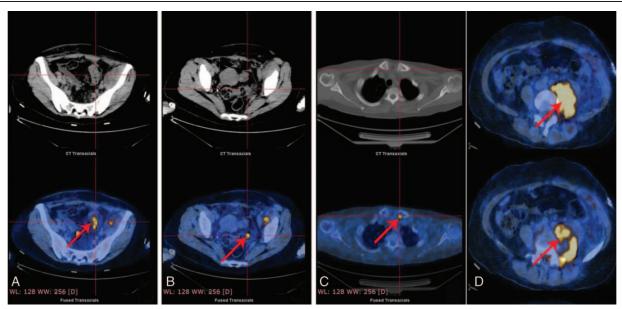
¹⁸F-FDG (fluorodeoxyglucose) positron emission tomography - computed tomography. (A) The arrow showed the sigmoid colon wall thickening with hypermetabolic foci and abnormal radioactivity concentration. (B) The arrow showed the multiple lymph nodes in pelvic cavity with hypermetabolic foci and abnormal radioactivity concentration. (C) The arrow showed the bone destruction of left extremitas sternalis claviculaeta with locally hypermetabolic foci and abnormal radioactivity concentration. (D) The arrows showed the swelling psoas and iliopsoas with low density, heterogeneous hypermetabolic foci, and abnormal radioactivity concentration.
